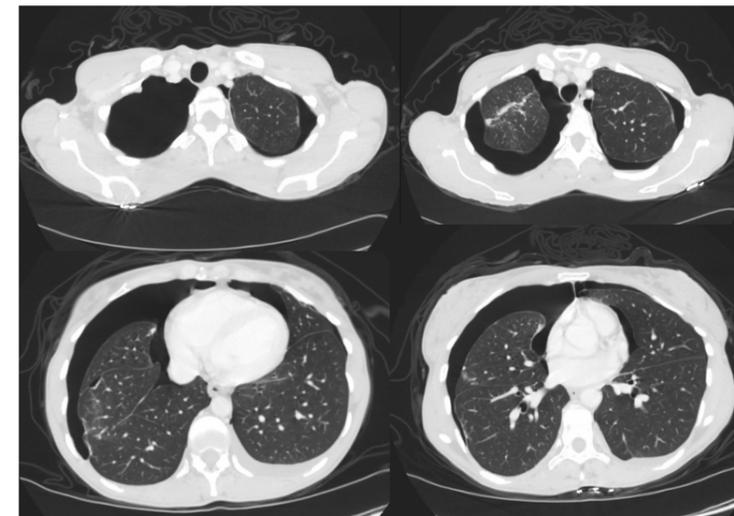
CT Chest with contrast
